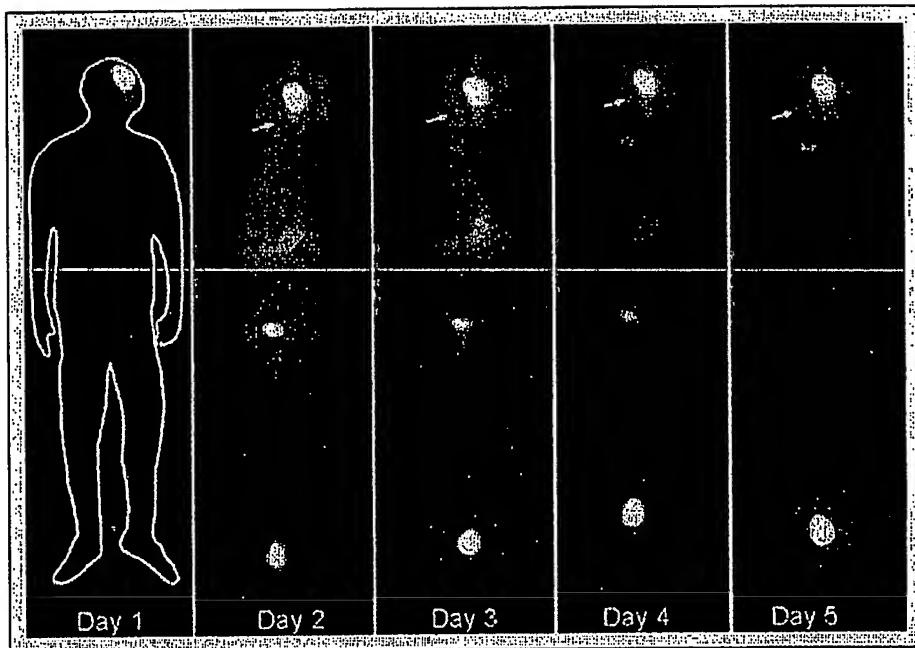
Gamma camera scans. Anterior gamma camera scans for patient 104. Intense localization is seen in the surgical cavity as late as 5 days after infusion. This result was confirmed on brain single photon emission computed tomography scans and was observed uniformly in all patients. Note the location of hot spots outside the surgical cavity (arrows).
